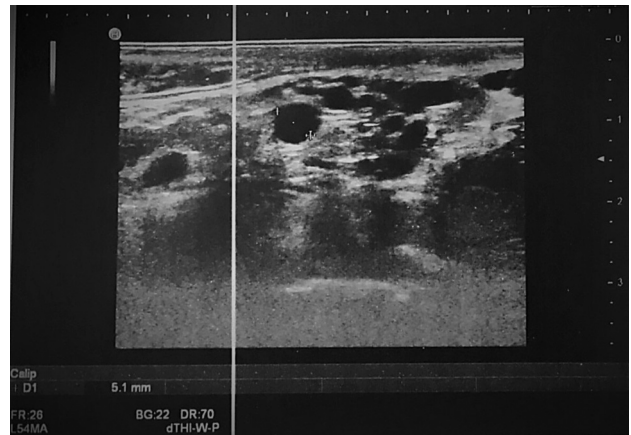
Multiple serpiginous lesions with anechoic view and tubular and round shapes were found in gray scale ultrasonographic examination.
